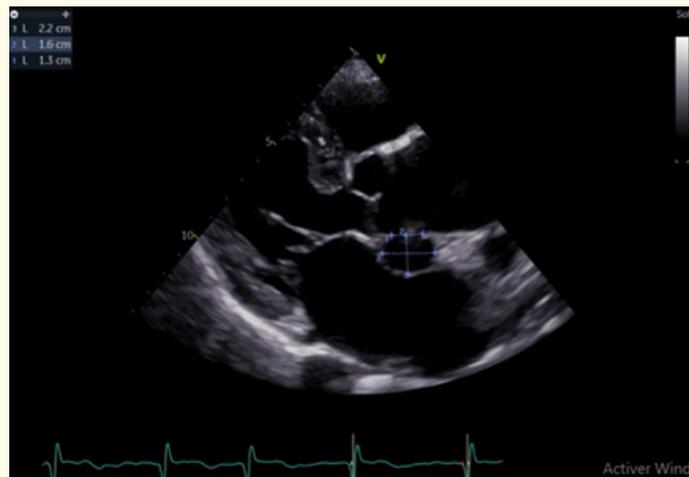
Parasternal long axis view demonstrating a parietal outpouching near the posterior wall of the left coronary cusp, measuring 22 mm long axis, evoking a penetrating aortic ulcer of the ascending aorta.
